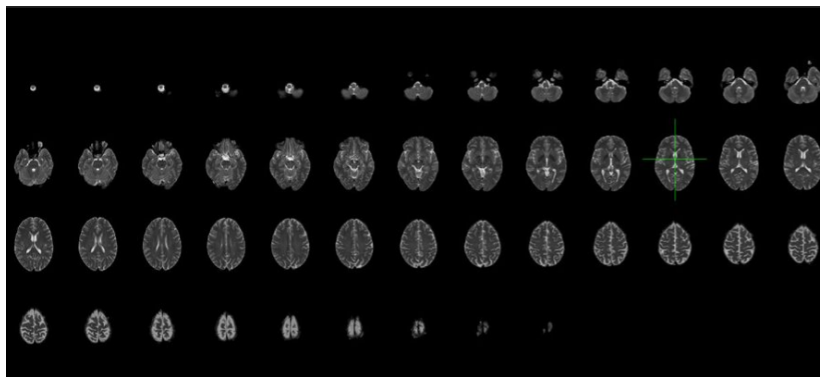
T2 MRI of a subject consisting of 48 slices
